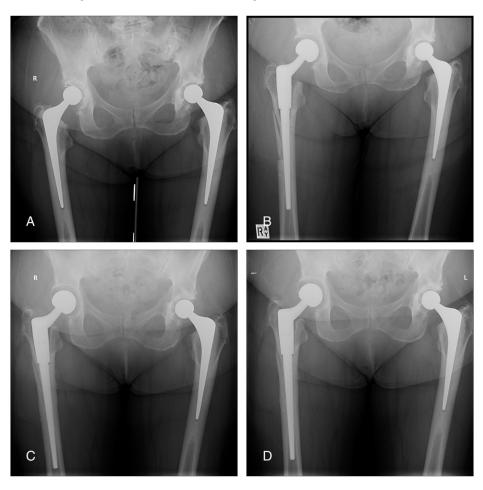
Radiographs of a successful restoration stem preoperatively (A), immediate postoperatively (B), 1-year postoperatively (C), and 2-year postoperatively (D).
